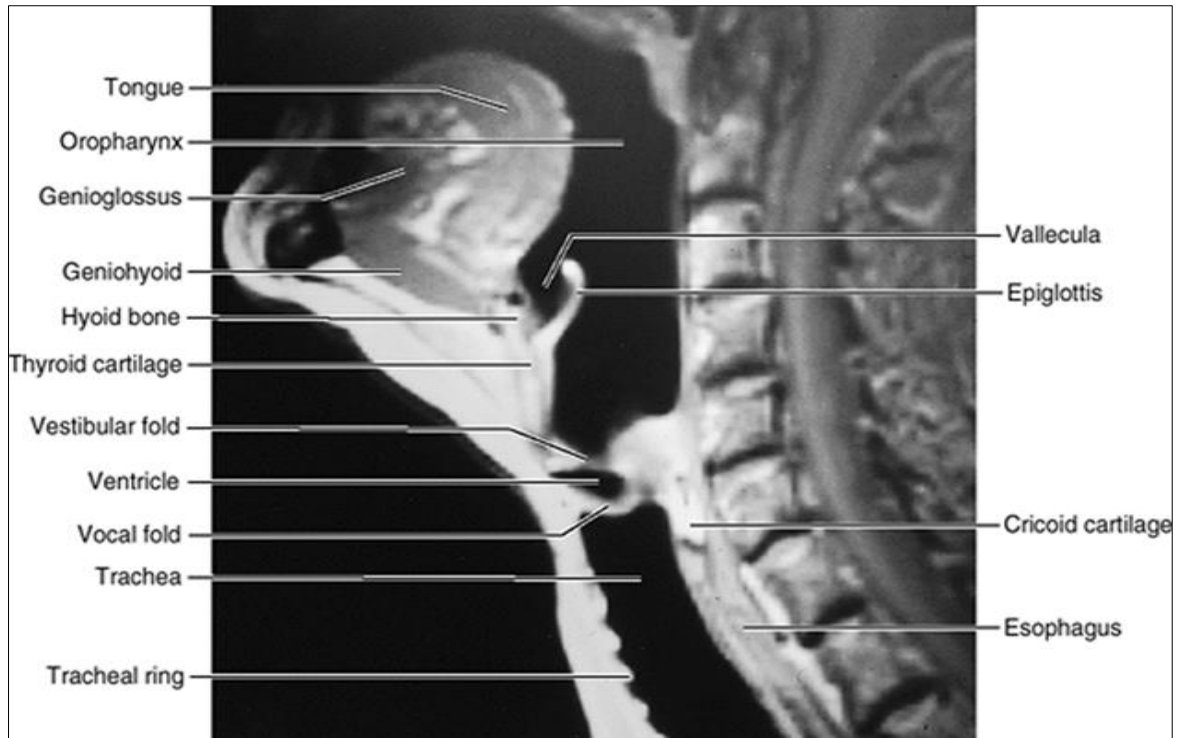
MRI of the Neck- Courtesy; Keith Moore& Arthur Dalley
